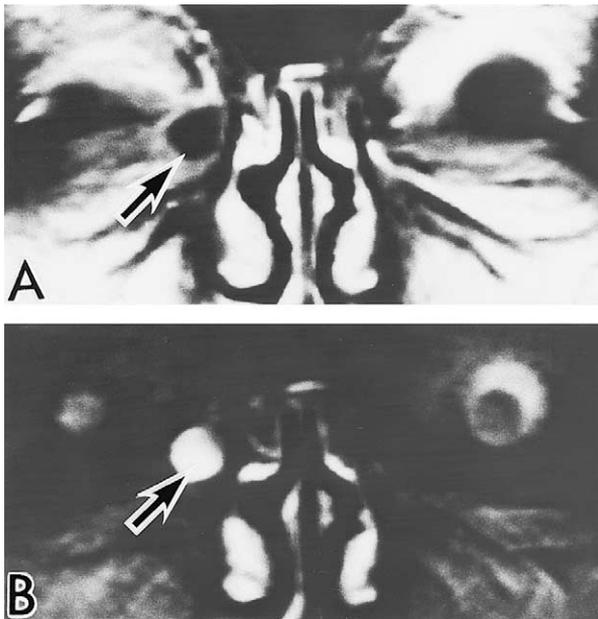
Magnetic resonance imaging coronal sections of a patient (case 3) treated by standard external dacryocystorhinostomy (A) T₁-weighted image after enhancement with gadolinium-diethylenetriamine pentaacetic acid shows the right lacrimal sac wall to be slightly hyperintense with increased contrast between the interior and the wall (arrow). (B) T₂-weighted image shows the lacrimal sac interior to be homogeneously hyperintense (arrow).
